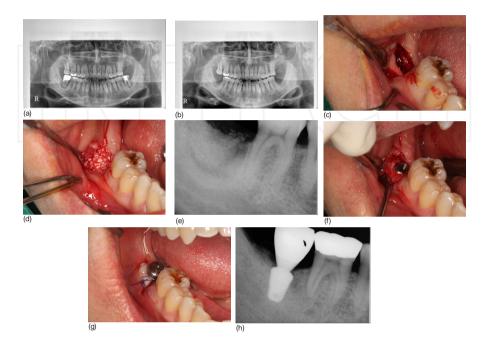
Extraction socket graft and delayed implant placement were performed on a 48-year-old male patient. (Kim Y.K., et al. Extraction socket preservation and reconstruction using autogenous tooth bone graft. J. Korean Assoc. Maxillofac. Plast. Reconstr. Surg., 2011.). a): Initial panoramic radiographic view, Periapical radiolucent lesion was observed at #37, 47 area. Radiolucent lesion was extended to the vicinity of the inferior alveolar canal. b):. Panoramic radiograph 3 months after extraction. c): The mucoperiosteal flap was elevated for implant placement 3 months after #47 extraction. The healing of extraction socket was poor. It was impossible to install the implants because of inadequate stability. d): Autogenous tooth bone graft powder was grafted into the socket. e): Postoperative periapical radiograph. f): Implant was installed 3 months after socket graft. Primary implant stability was excellent. g): Second surgery was performed 2.5 months after implant placement. h): Periapical radiograph 14 months after the final prosthetic delivery.
